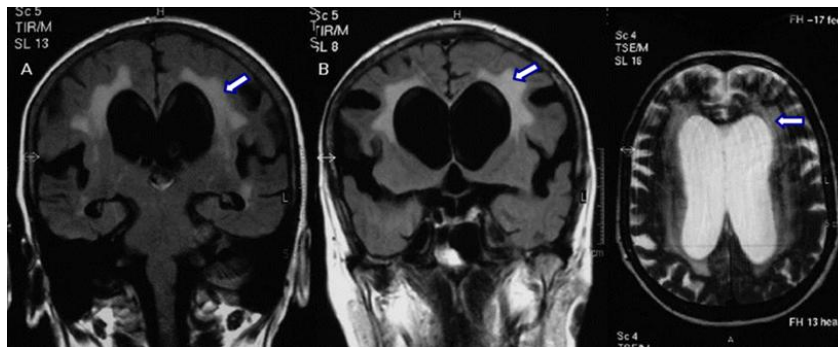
MRI image of hydrocephalus with transependymal CSF resorption (⇔)
